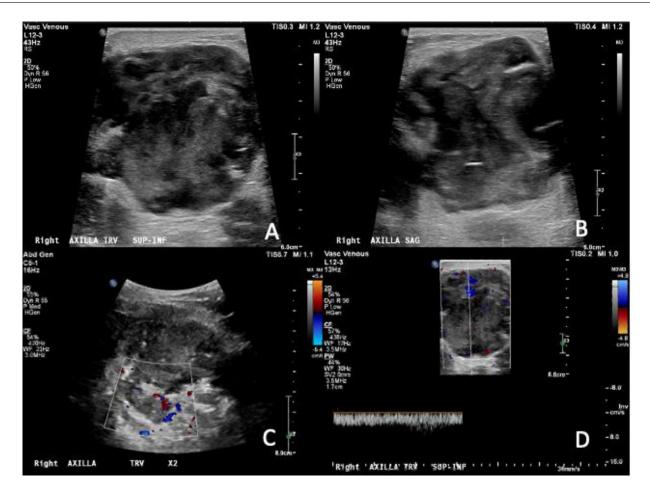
Ultrasound of the left axilla performed for pain and swelling after mastectomy. Duplex ultrasound of the left axilla in the transverse (A) and sagittal (B) planes demonstrates a complex cystic and solid mass with irregular margins with areas of internal vascularity (C, D).
